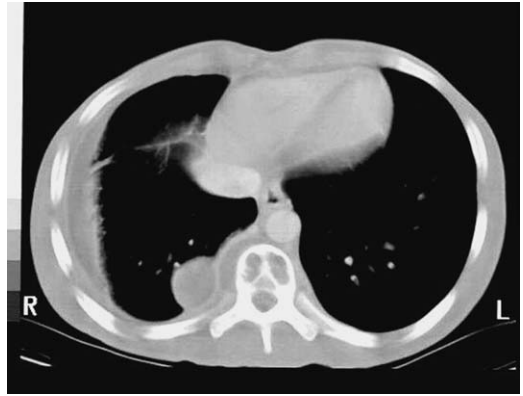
CT of tuberculosis of the spine, Pott's disease.
